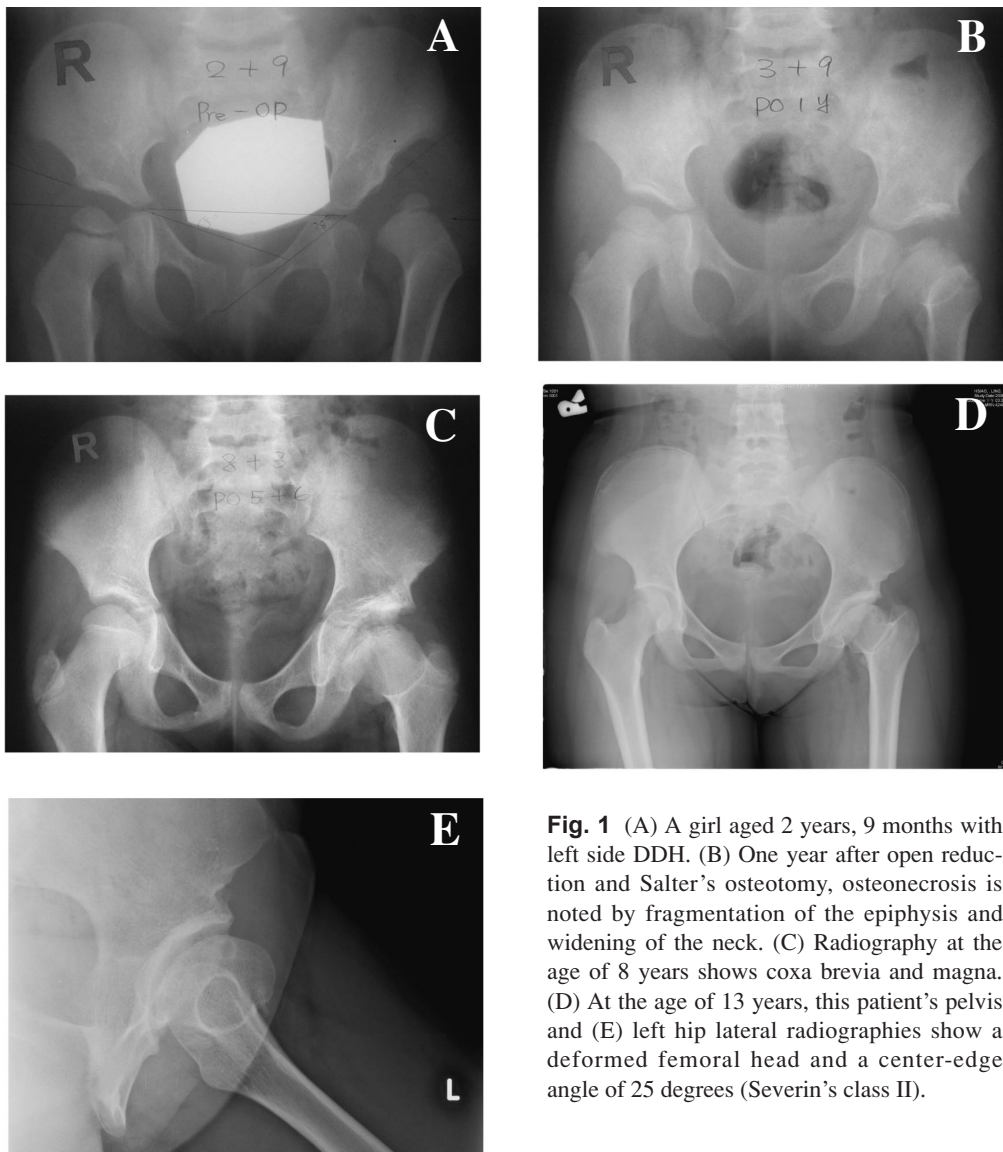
(A) A girl aged 2 years, 9 months with left side DDH. (B) One year after open reduction and Salter's osteotomy, osteonecrosis is noted by fragmentation of the epiphysis and widening of the neck. (C) Radiography at the age of 8 years shows coxa brevia and magna. (D) At the age of 13 years, this patient's pelvis and (E) left hip lateral radiographies show a deformed femoral head and a center-edge angle of 25 degrees (Severin's class II).
